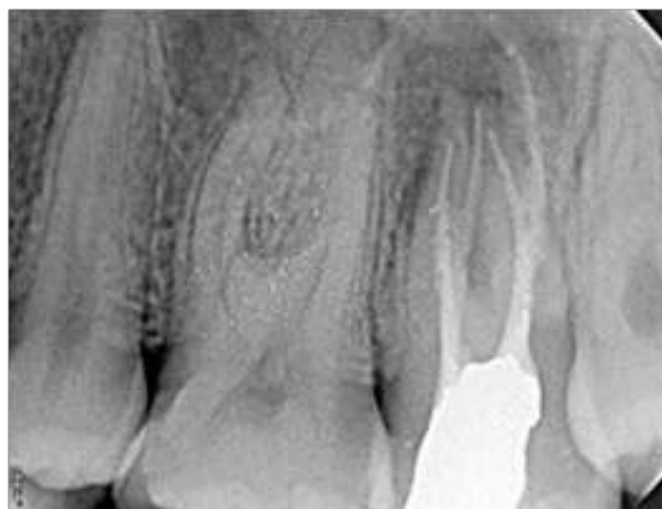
Radiograph after obturation
